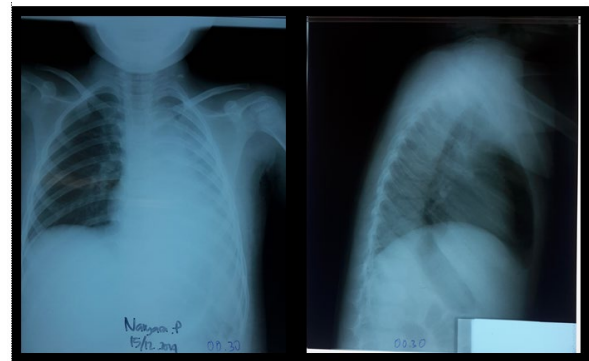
Thorax X-ray examination AP-lateral position before operation
